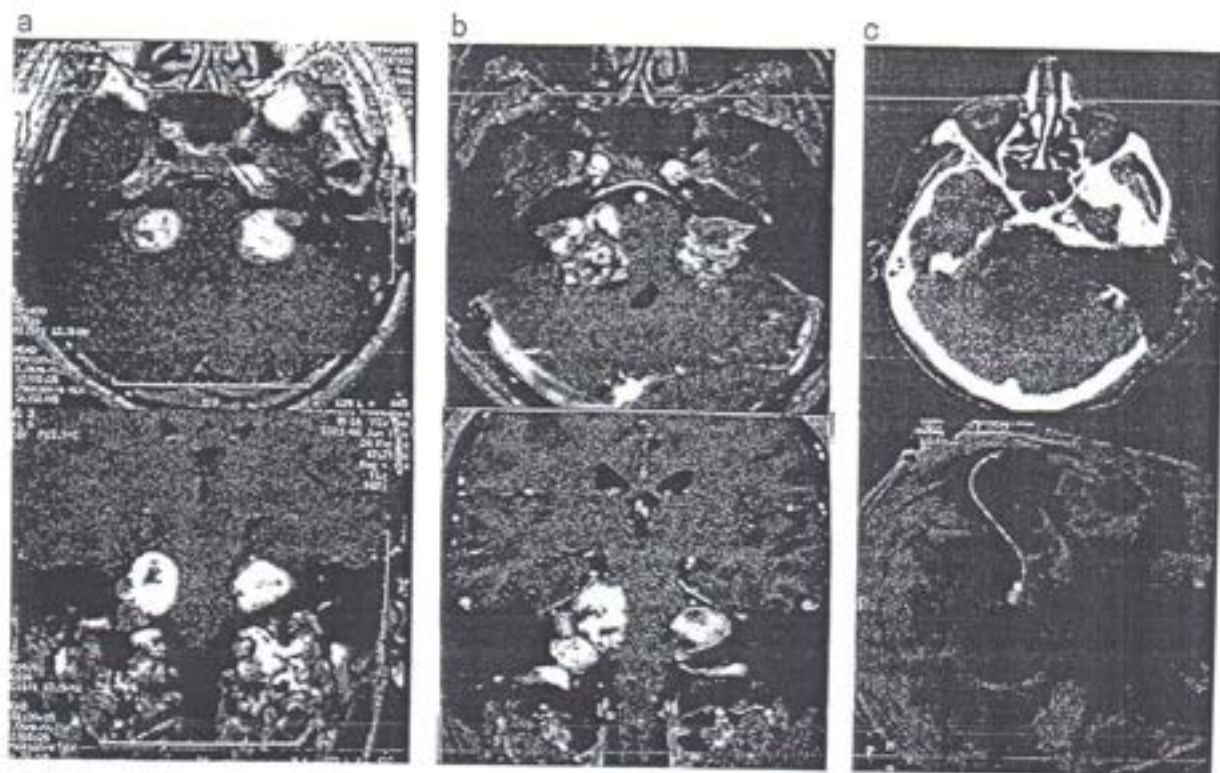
(a) T1 gadolinium-enhanced axial and coronal MR images demonstrated bilateral VS and right lower cranial nerve tumor in NF2 patient (in 2001). (b) Gadolinium-enhanced axial and coronal MR images showing growth of bilateral tumors in 2006. (c) Postoperative CT scan with 3D reconstruction revealed total resection of the left side tumor with the ABI in place.
